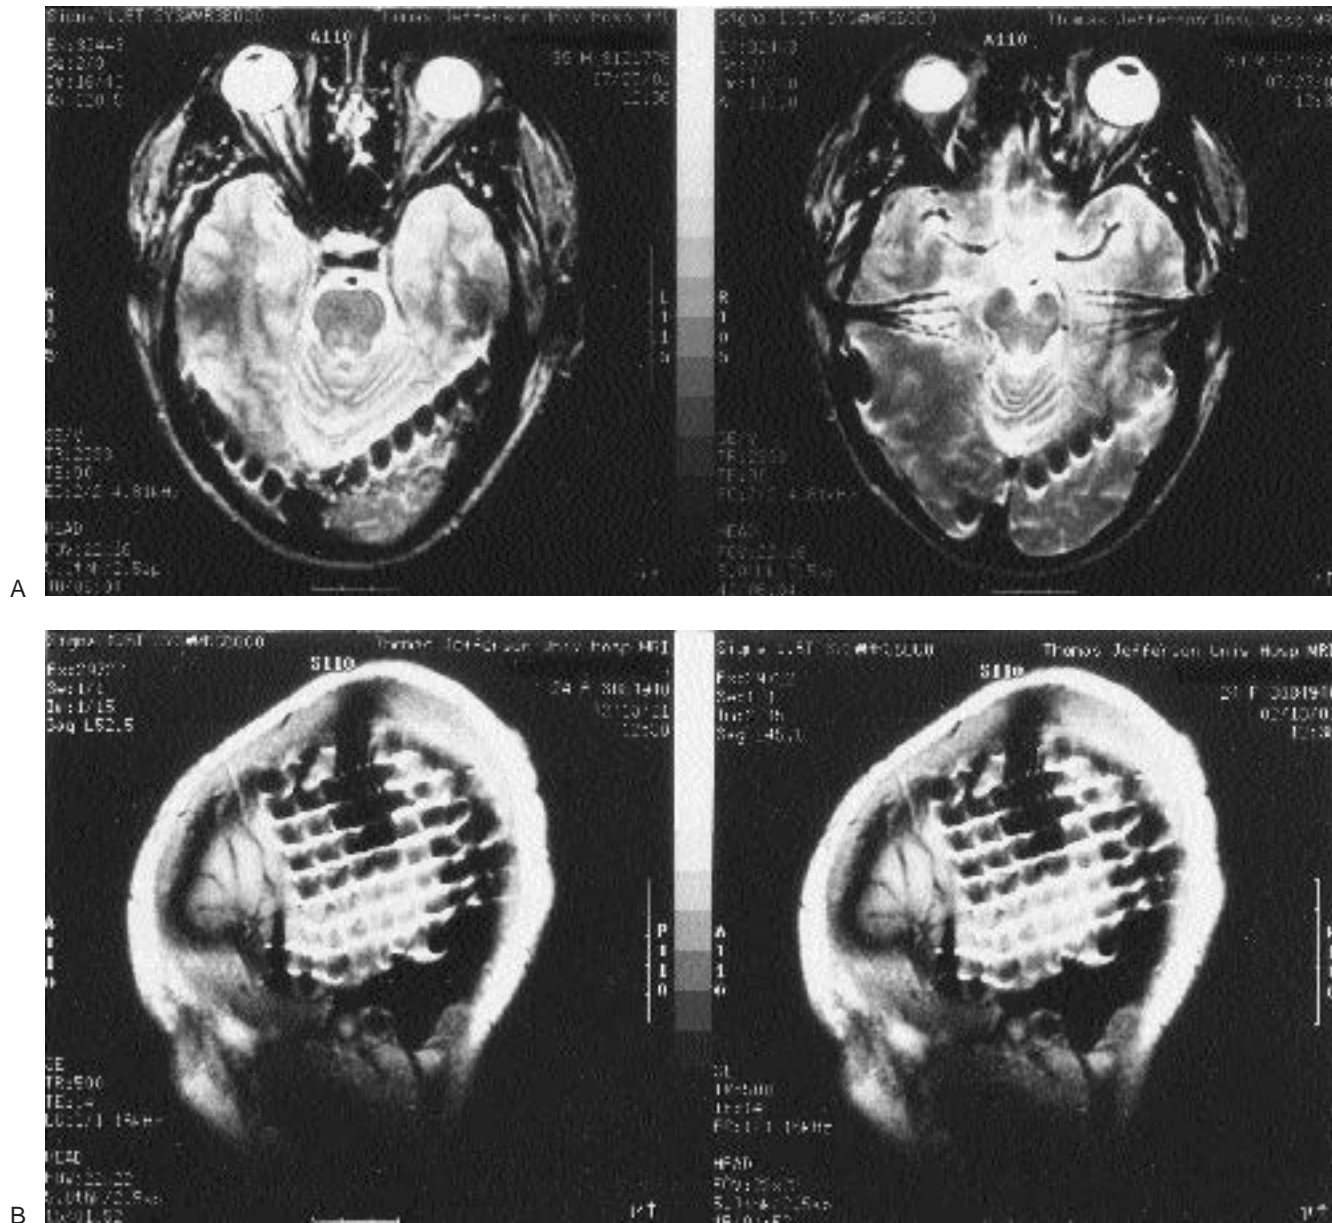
A: MRI axial section showing depth and subdural electrodes. The depth electrodes are seen entering the lateral temporal cortex and crossing to the mesial cortex. Subdural electrodes are shown running posteriorly. B: MRI sagittal view showing subdural grid electrode contacts overlying the left hemisphere.
